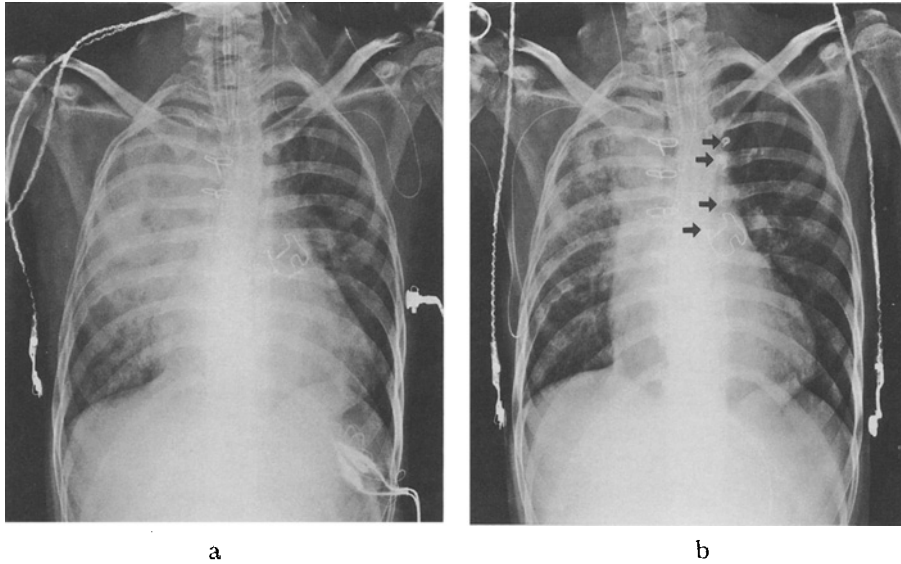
a. Digital chest radiography before embolization. Airway consolidation in right upper and middle lung fields, and cardiomegaly are present.
